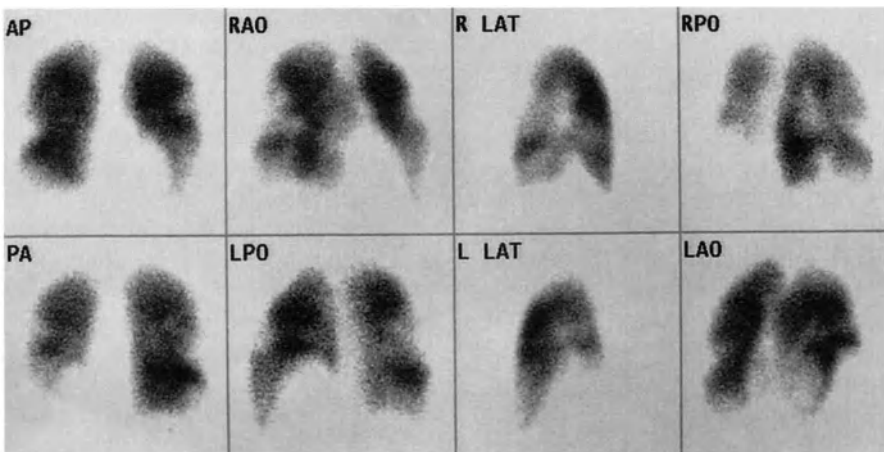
Ventilation-perfusion scintigraphy, 3 weeks after the beginning of the illness. The bright areas represent distribution or absent perfusion due to multiple pulmonary emboli
